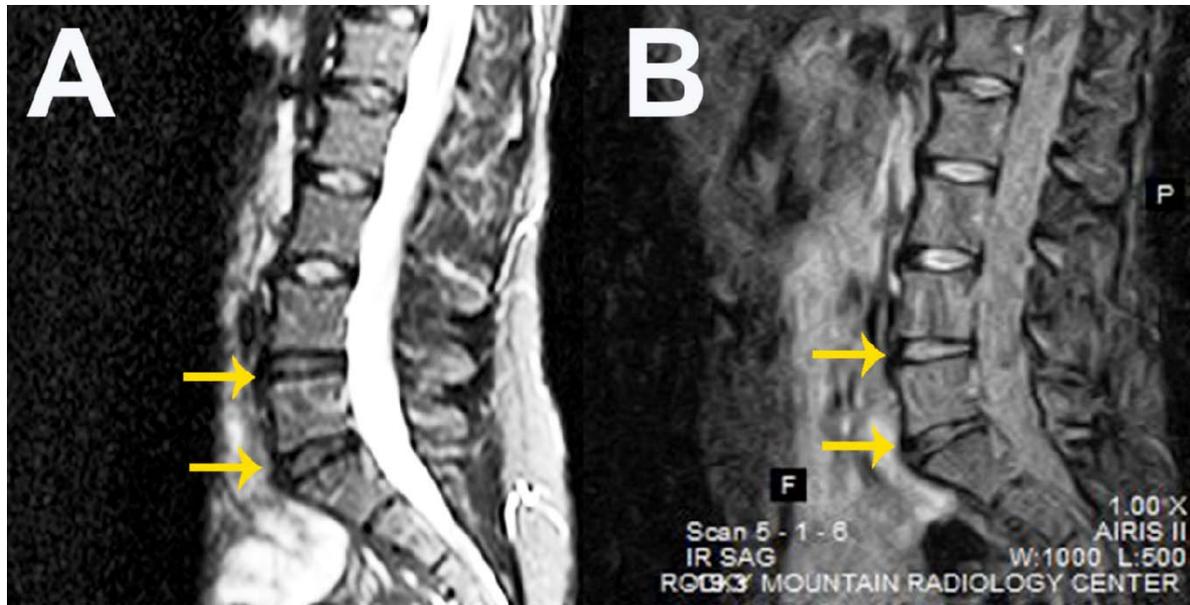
Magnetic resonance image (MRI) before pre-treatment (A) and 12 months after injection (B) of autologous BMC into L4-L5 and L5-S1 intervertebral discs. L4-L5 improved from grade 5 to grade 4 while L5-S1 remained at grade 6. (C) Pre-treatment and 12 month modified Pfirrmann MRI scores for one-level and two-level intervertebral disc injections by blinded independent reviewer and number of patients who showed improvement of one grade among the 20 patients completed 12 month MRI (* Two patients elected for surgical intervention and four non-surgical patients did not receive 12 month follow-up MRI).
